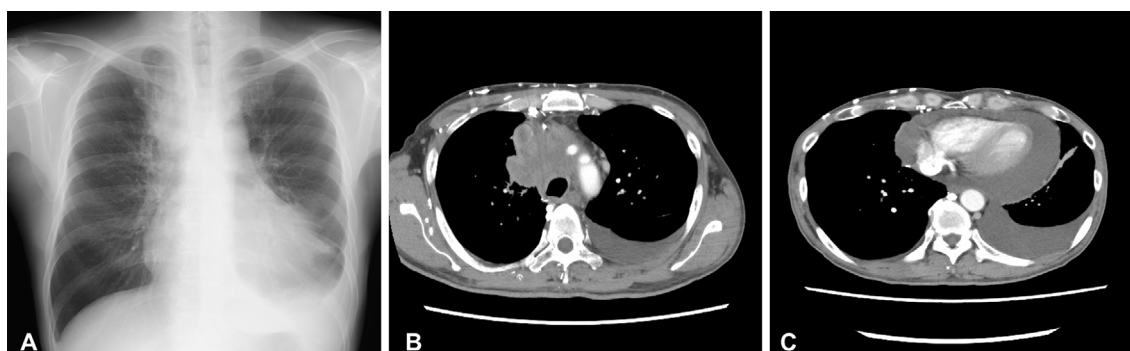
(A) Admission chest X-ray showing a mediastinal mass, left pleural effusion and enlarged cardiac silhouette. (B, C) Contrast-enhanced computed tomography revealed superior vena cava obstruction by a large lung mass with mediastinal invasion, left pleural effusion and marked pericardial effusion.
